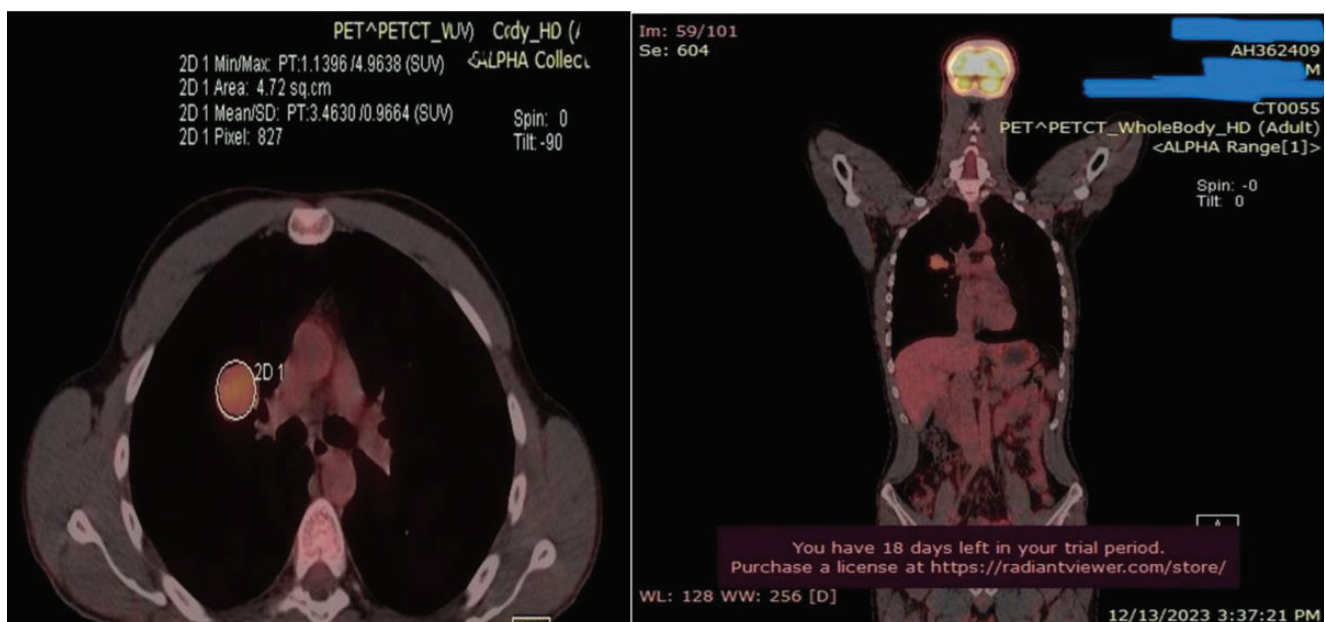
PET/CT all-body. A solitary right nodule LSD 28x22mm, SUVmax 4.9 (Cut off SUVmax in tumors over 2.0). There are no pathological hilar, mediastinal, and supraclavicular lymph nodules. There is no data on pathological fixation of 18F-FDG in the liver, bone, or spleen.
